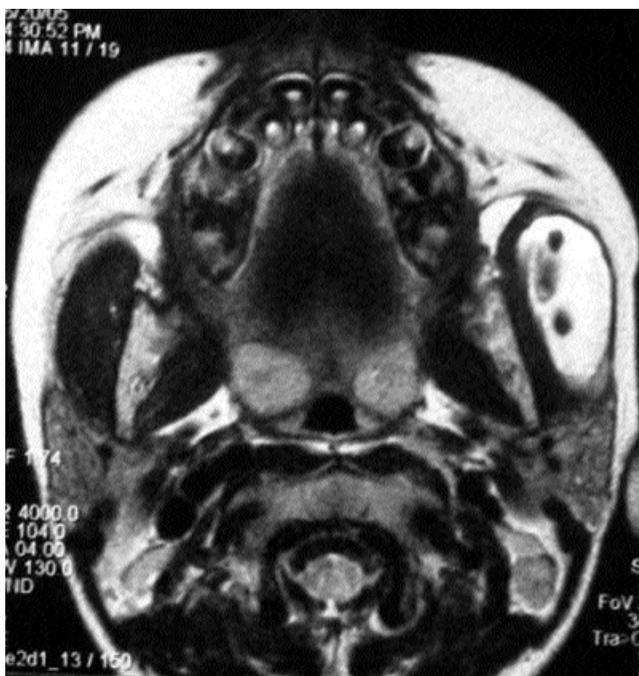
Hyper intense lesion in left masseter on MRI.
